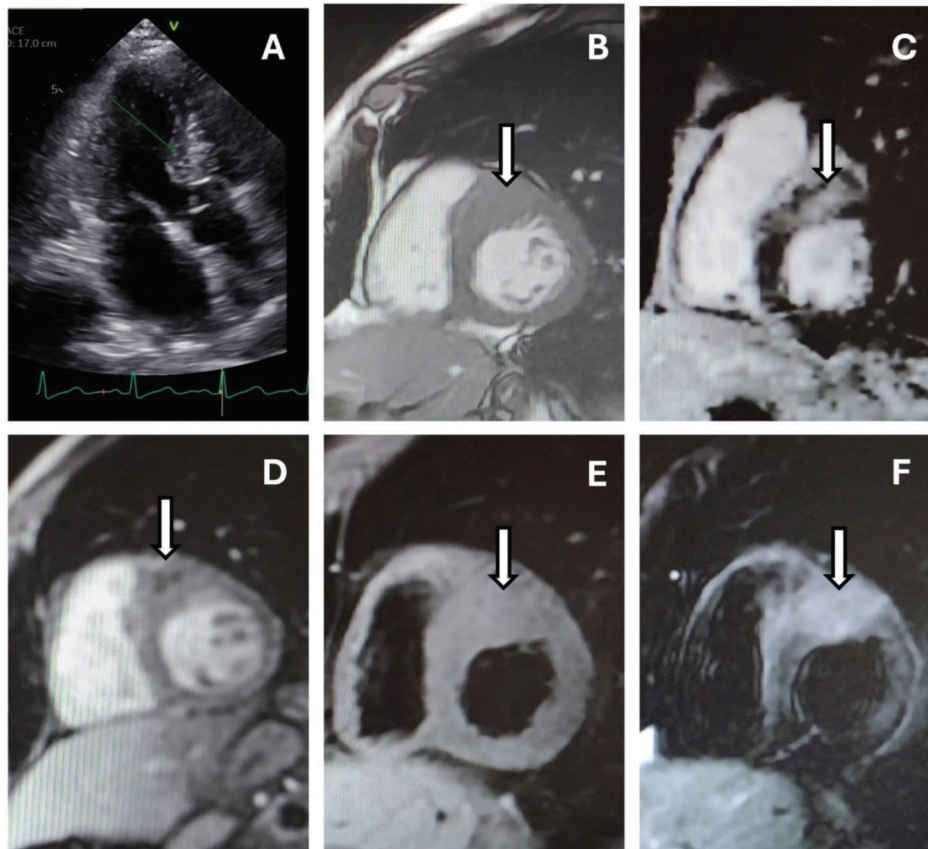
Patient 4 Multimodal imaging of cardiac metastasis. Panel A: 2D transthoracic echocardiogram (TTE), apical three-chamber view, showing a suspected mass (green arrow) in the basal anteroseptal wall. Panels B–F: Cardiac magnetic resonance (CMR) sequences. Panel B: Cine short-axis view. Panel C: Late gadolinium enhancement. Panel D: Perfusion image. Panel E: T1-weighted sequence. Panel F: T2-weighted sequence. All CMR images (white arrow) reveal a well-defined lesion in the basal anterior and anteroseptal wall (28 × 25 × 33 mm), consistent with a metastatic deposit. The lesion exhibits an isointense signal on T1-weighted imaging, a hyperintense signal on T2-weighted imaging, a central non-enhancing component on perfusion imaging, and heterogeneous enhancement on delayed gadolinium enhancement sequences.
